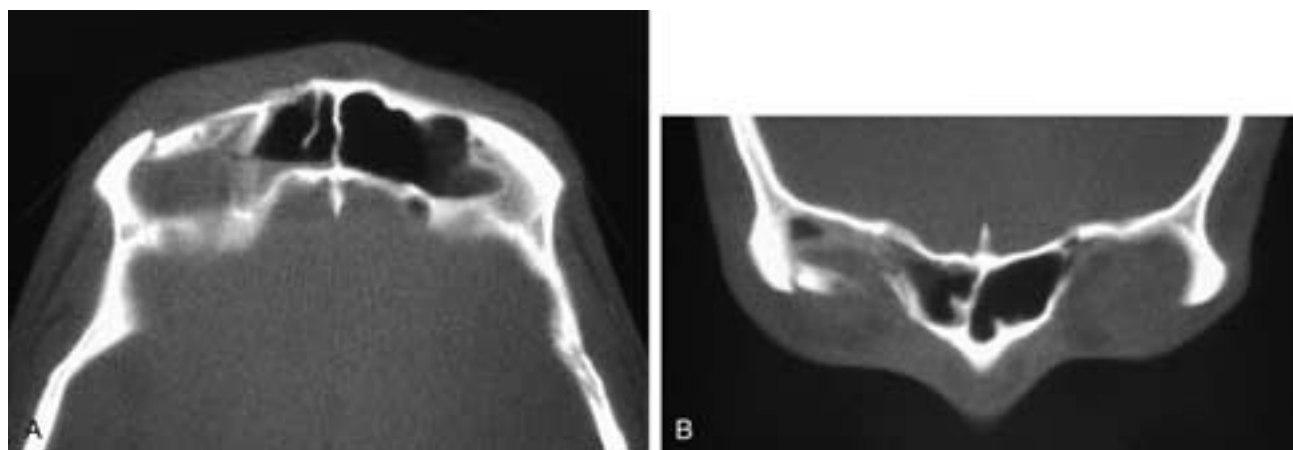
Axial (A) and coronal (B) CT scans show a fracture involving the right orbital roof and the lower anterior frontal sinus table.
